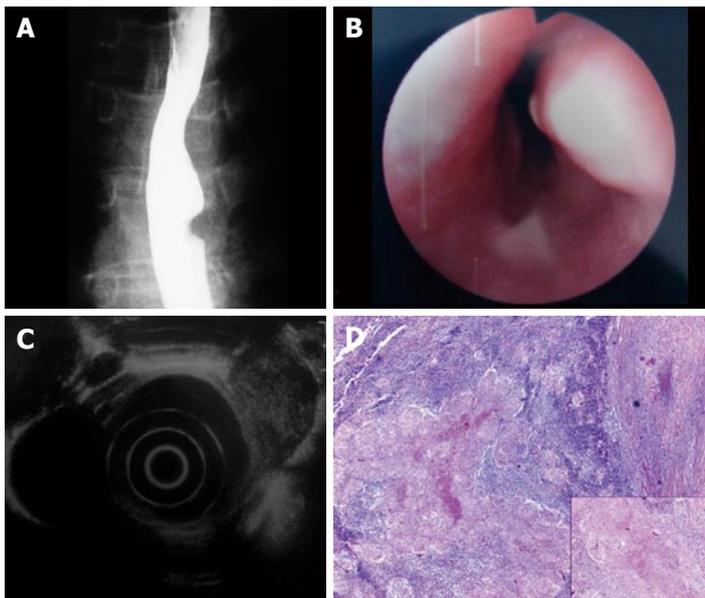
Barium swallow showing a two-centimeter protruding lesion on the left lateral aspect of the mid-esophagus (A), and endoscopic view of a two-centimeter protruding lesion covered by normal mucosa and with firm consistency (B), endoscopic ultrasonography revealing a two-centimeter solid hypoechoic lesion in the third layer (C), and lymph node parenchyma extensively occupied by necrotizing epithelioid granulomas (HE, $\times 40$) (D). Insert: typical tuberculous granuloma with central caseous necrosis and multinucleated cells of Langhans type (HE, $\times 200$).
